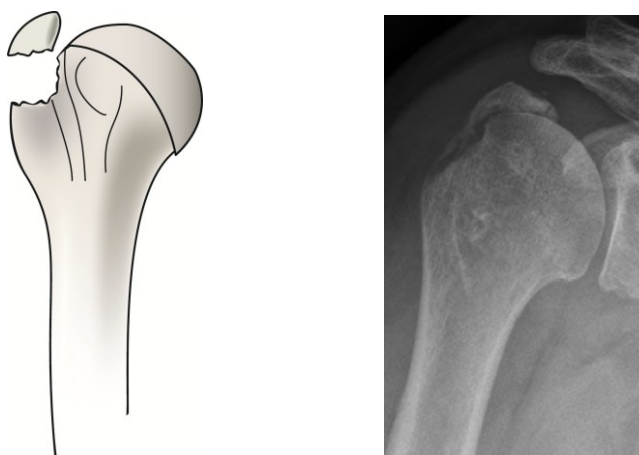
/Radiograph 1: An artist's rendition and anteroposterior radiograph of the typical Avulsion-type fracture. As seen here, the fragment is small, the fracture line is horizontal, and displacement is superior and medial.
